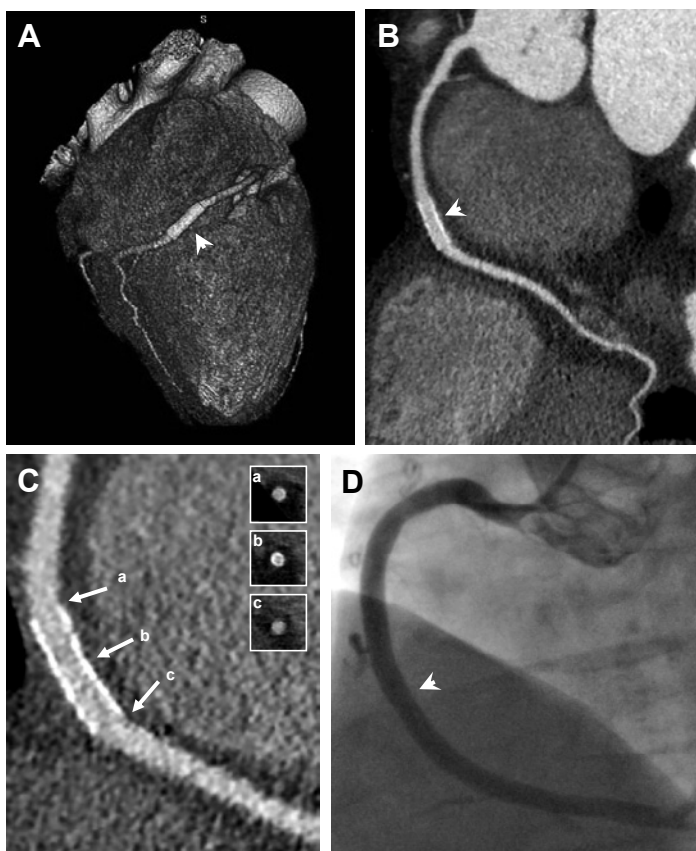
320-row CTA of a patent stent (Ultra, 4.5 mm x 18 mm) in the RCA of a 60 year-old male patient. Panel A shows a three-dimensional volume rendered reformation of the heart showing an overview of the RCA with a stent (arrowhead) in segment 2. Panel B depicts a curved multiplanar reconstruction of the RCA showing a patent stent (arrowhead). Panel C shows a curved multiplanar reconstruction using a sharp convolution kernel. In the upper right-hand corner, transverse sections of the stent and both stent edges (arrows) help confirm the absence of in-stent hyperplasia. An invasive coronary angiogram in panel D confirmed the observation.
